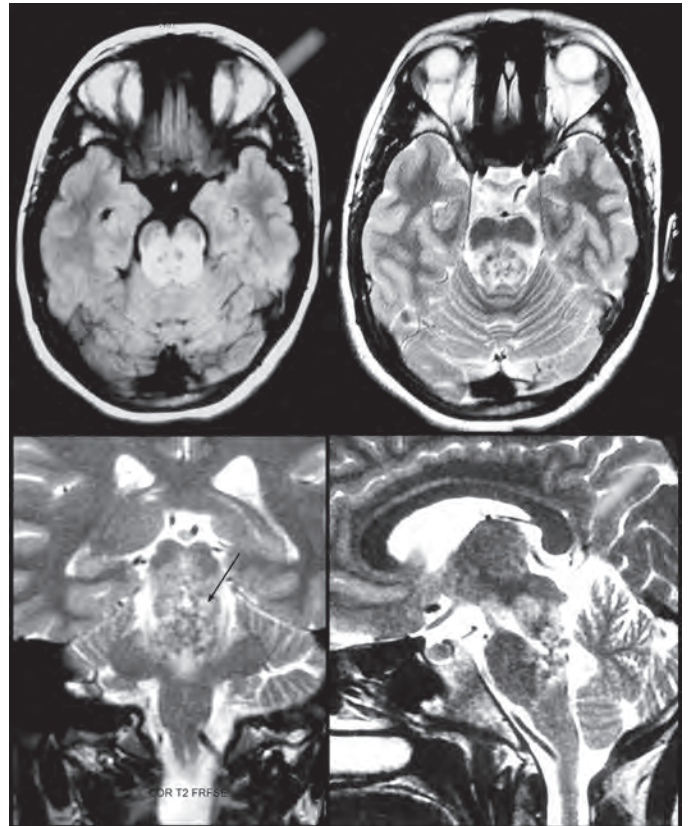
MRI of the brain showing brainstem cavernoma with popcorn appearance
